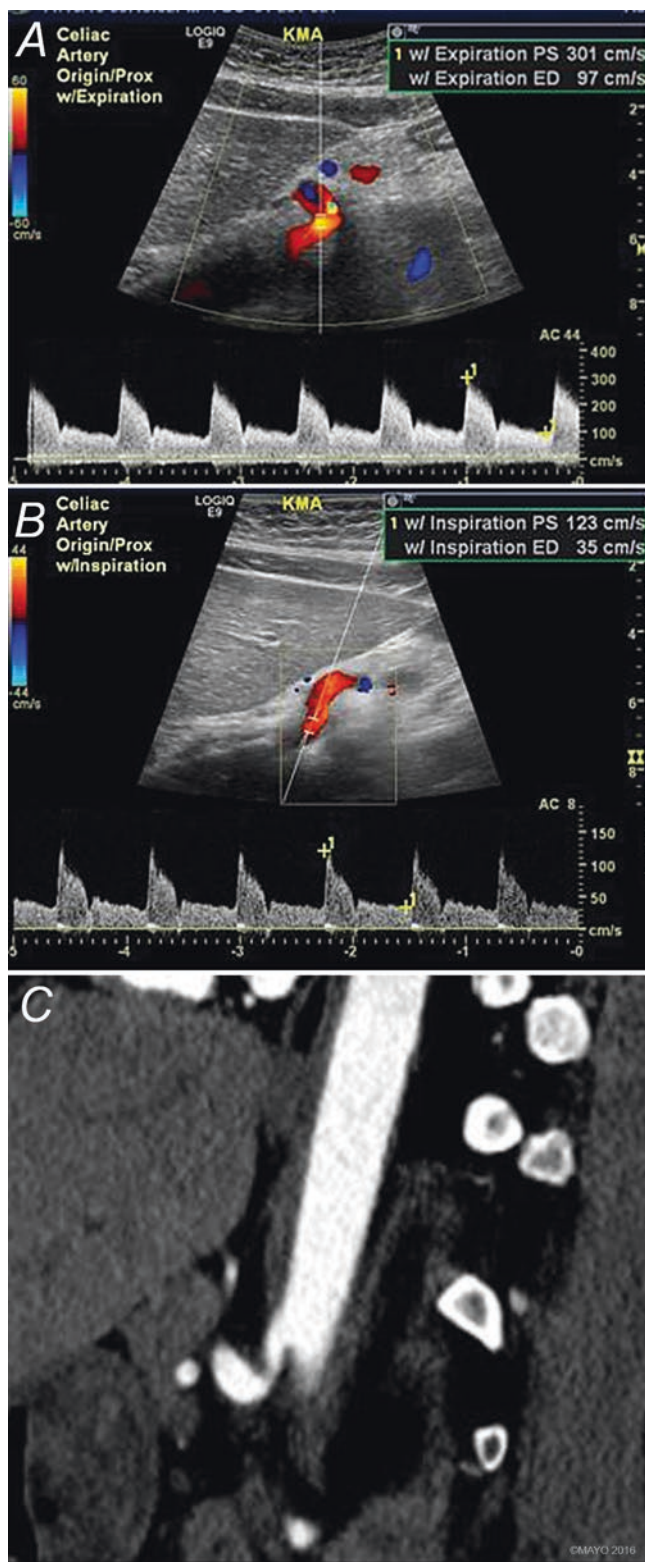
Duplex ultrasound shows dynamic compression of the celiac artery during expiration (a) and normalization during inspiration (b). CT correlation (c) confirms the typical “hook” appearance related to median arcuate ligament compression during expiration. These findings in the appropriate clinical context are suggestive of median arcuate ligament compression syndrome. By permission of Mayo Foundation for Medical Education and Research. All rights reserved
